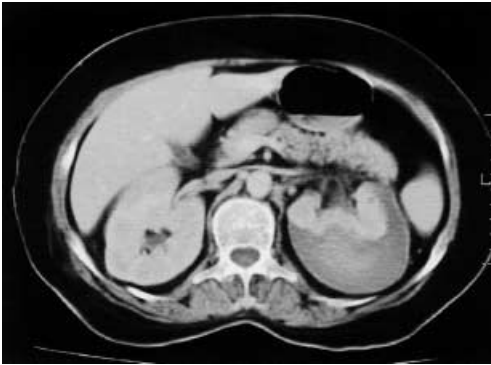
The initial CT scan showed subcapsular haematoma without identifying the bleeding source.
